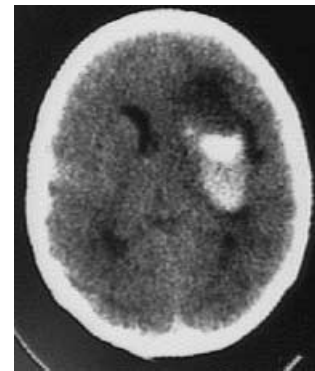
CT scan showing a deep hemorrhagic lesion in the right fronto-parietal region with perilesional edema in an 8-year-old girl with Henoch-Schoenlein syndrome (HSS)
